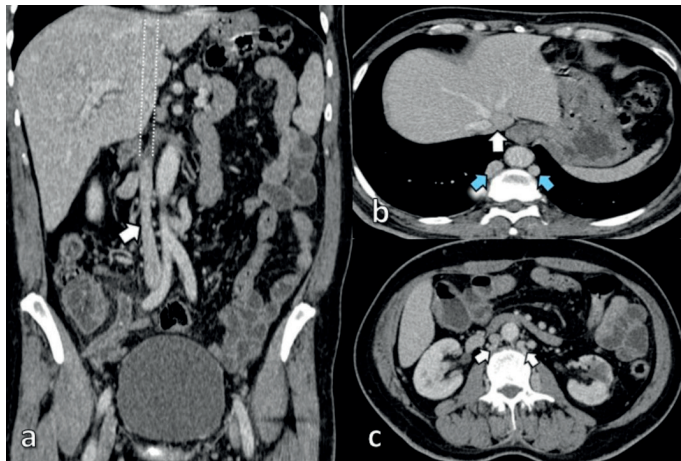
On coronal CT image (a), infrarenal IVC is intact (white arrow), whereas the suprarenal portion of the IVC is absent (white dots). (b) The intrahepatic IVC is intact and the hepatic veins drain into the hepatic segment of the IVC (white arrow) on axial CT image. (c) The interrupted IVC continues by the help of lumbar venous plexus (white arrows) on axial CT image and drains into the azygos and hemiazygos venous system on axial CT image. You can see enlarged azygos and hemiazygos veins (blue arrows) on image b.
